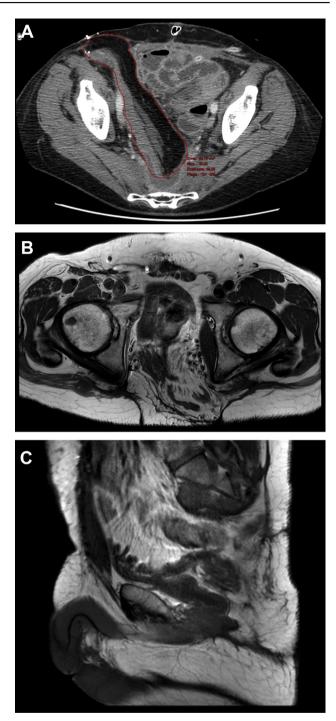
Radiological volumetric analysis with an example of flap surface measurement (A). MRI (patient 2, 1 year postoperatively) confirming flap stability over time with no collections or dead space without bowel herniation. Both ALT + VL flap and omentum flap participate in filling the anteroposterior defect (B,C).
